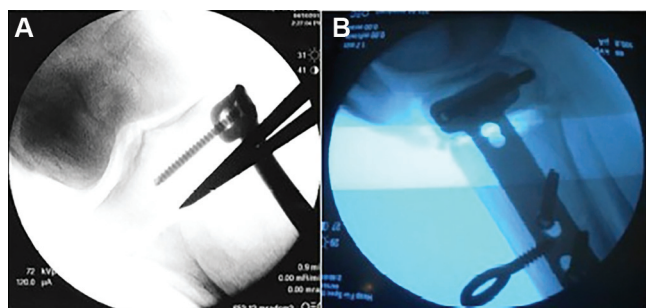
Intraoperative radiographs of a medial opening-wedge high tibial osteotomy. (A) Anteroposterior and (B) lateral radiographs demonstrate the osteotomy site and the Tomofix plate used to obtain fixation.
